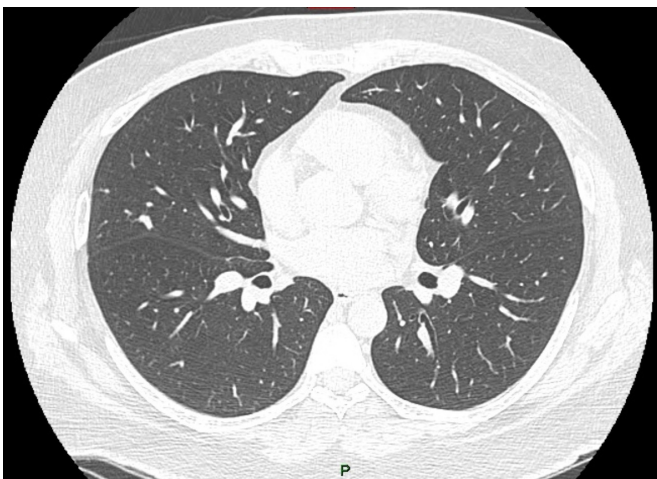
Chest CT scan 36 weeks after the initial *Pneumocystis jirovecii* pneumonia.
